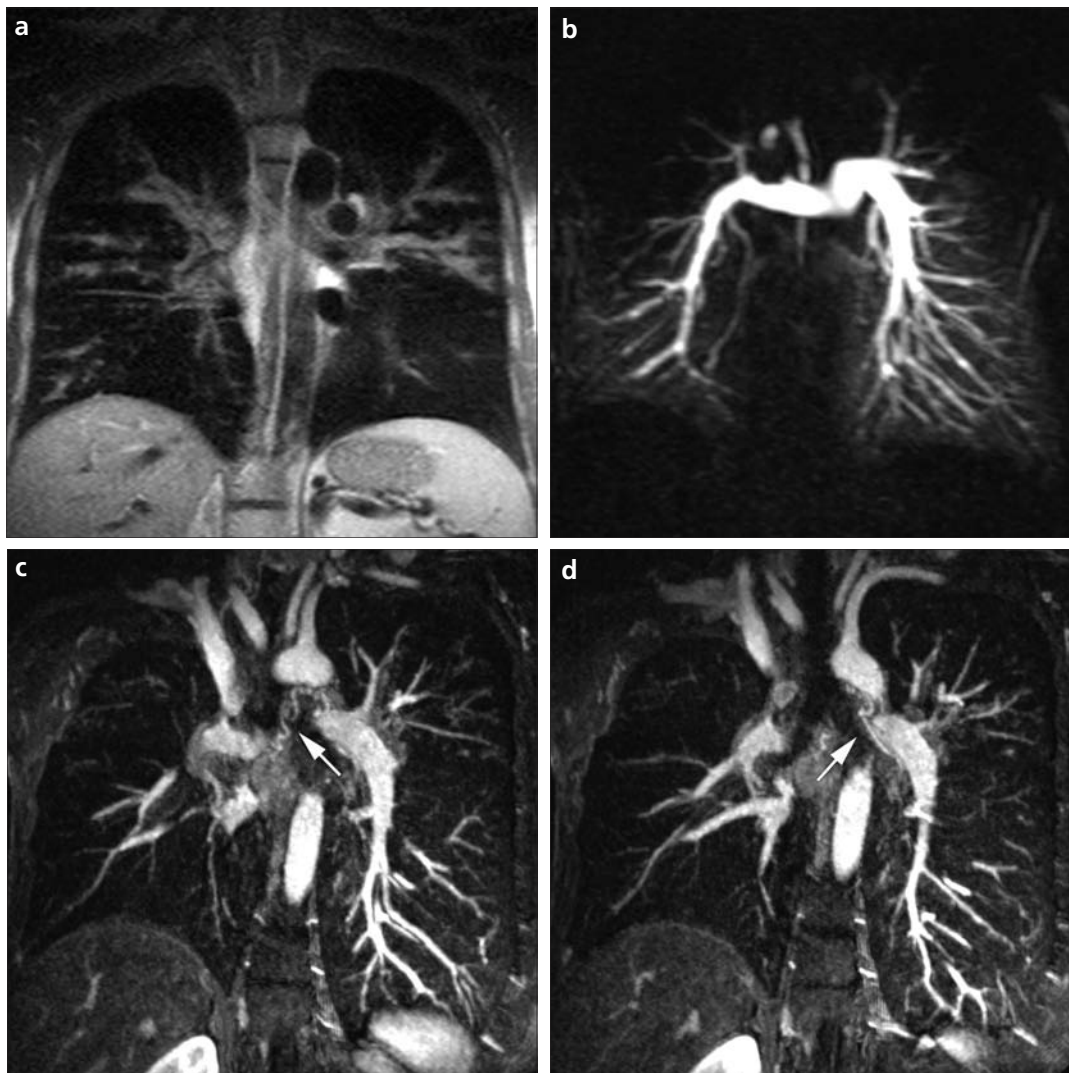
a–d. The coronal T2-weighted fast spin echo half-Fourier acquisition sequence (a) depicts severe wall-thickening and mucus plugging from lobar to distal bronchi in a 31-year-old patient with cystic fibrosis. Peripheral mucus plugging shows a grape-like appearance similar to the tree-in-bud phenomenon known from CT (left superior lobe, right inferior lobe). MR perfusion imaging (b) reveals extensive perfusion defects of both superior lungs (coronal maximum intensity projection [MIP], slice thickness 20 mm). Within the same examination, an MR angiography was acquired, which demonstrated dilated bronchial arteries (white arrows) to the right (c) and left lung (d) (double angulated MIP, slice thickness 10 mm). Courtesy of M. Puderbach, M. Eichinger and D. E. Optazaite, Heidelberg Thoracic Imaging Platform, Heidelberg, Germany.
